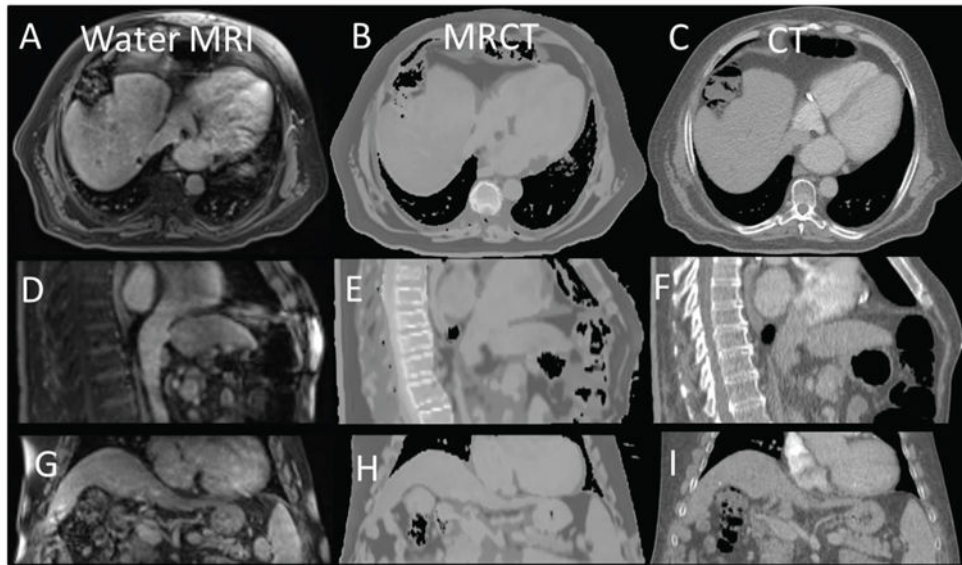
Co-registered axial, sagittal, and coronal views of the water MRI ((A), (D) and (G)) shown side by side with similarly windowed MRCTs ((B), (E) and (H)) and standard CTs ((C), (F) and (I)).
